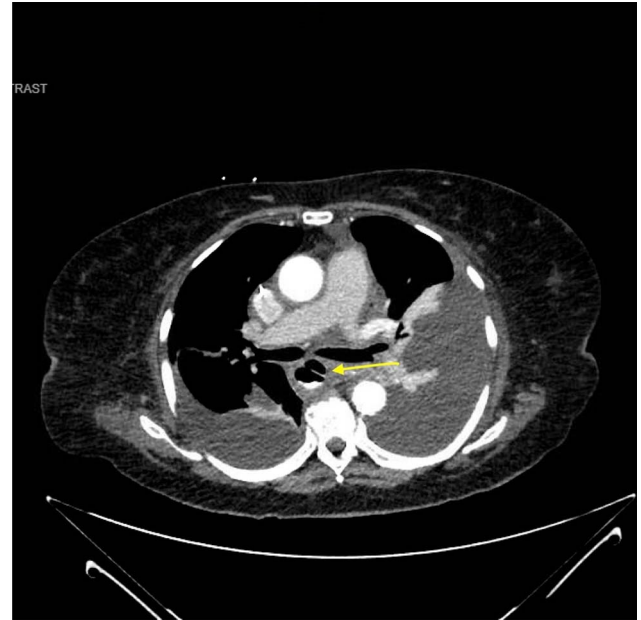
Computed tomography esophagram without extravasation of contrast into false lumen.
